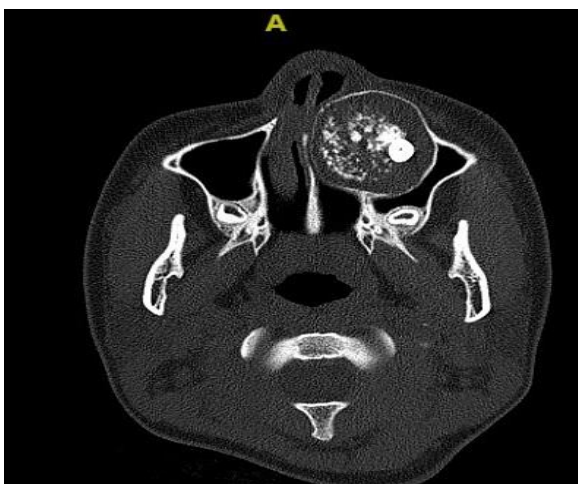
Axial CT scan of the patient showing the lesion is causing obliteration of the left nasal cavity and right lateral deviation of the nasal septum.
